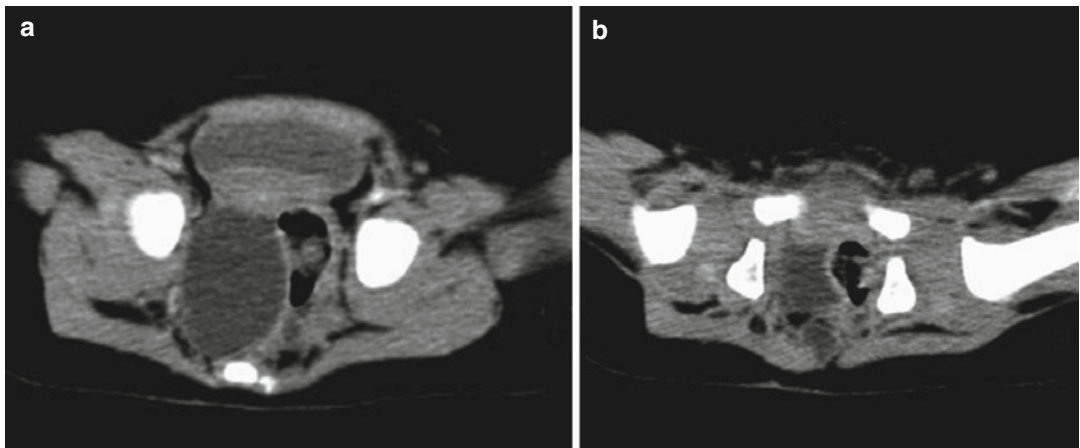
Female, 11-month years old. CT images show a predominantly cystic sacrococcygeal mass. A sacrococcygeal teratoma was then diagnosed
